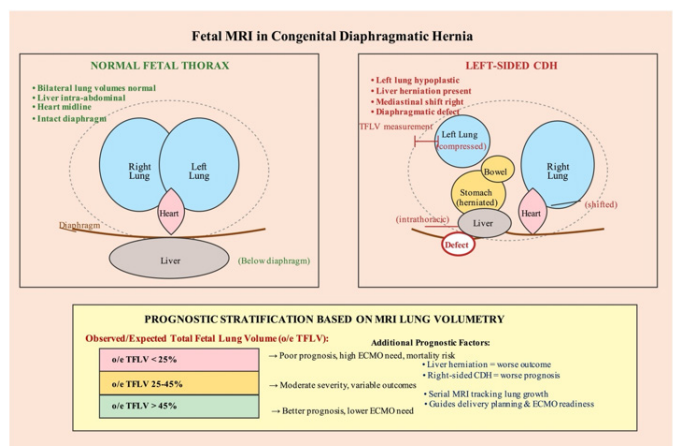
Fetal MRI findings in congenital diaphragmatic hernia with prognostic stratification
